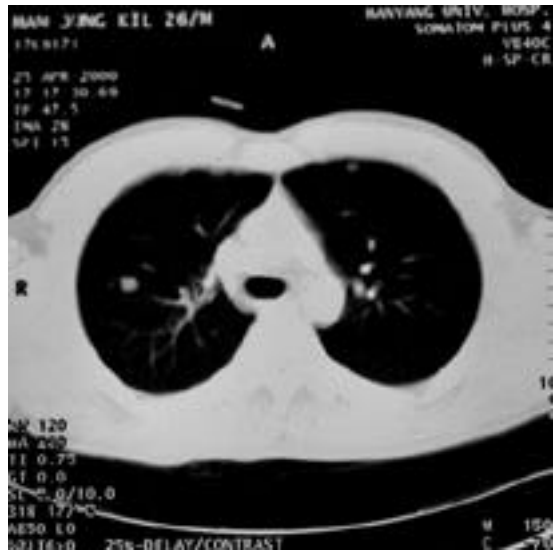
CT scan shows multiple metastatic pulmonary nodules 2 years after initial surgery.
